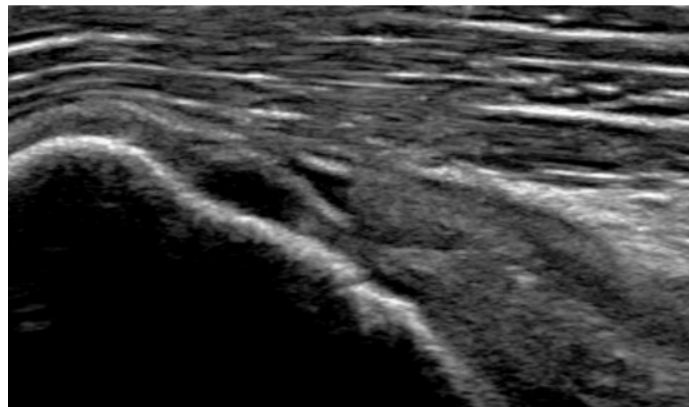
Longitudinal plane ultrasound image of supraspinatus tendon. Anechoic gap and pitting due to tear. Provided by the authors.
